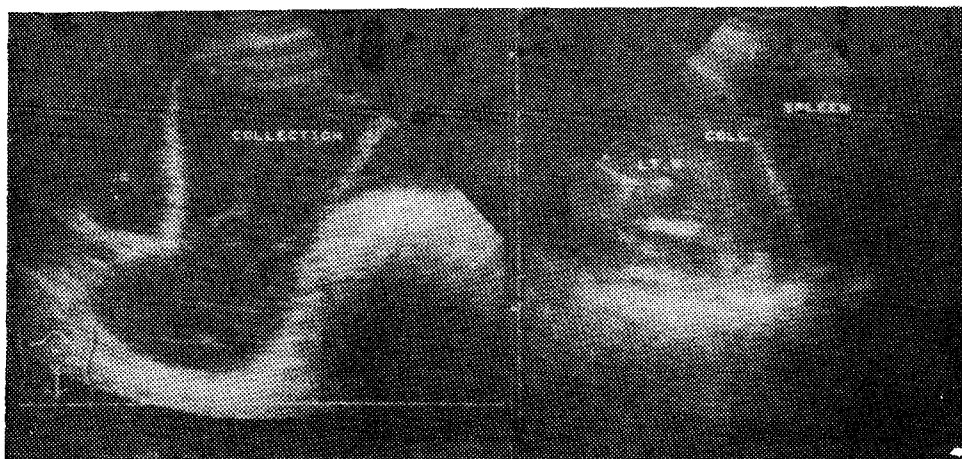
a) A child with blunt abdominal trauma. Ultrasonography showed distortion of the left renal outline with heterogeneous echo pattern, suggestive of parenchymal lesion. Large amount of perirenal haematoma is seen extending to the left pelvic region. Splenic tear is also seen at the upper pole. The patient was operated upon and left nephrectomy and partial splenectomy were done.
